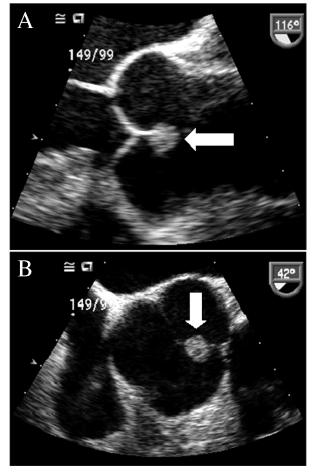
Transesophageal echocardiogram of the aortic valve. (A) short-axis view of aortic valve showing a well demarcated, rounded mass (arrow) attached to the free edge of the right coronary cusp consistent with papillary fibroelastoma; (B) long-axis view of aortic valve with the papillary fibroelastoma attached to the aortic side of the aortic valve (arrow)
